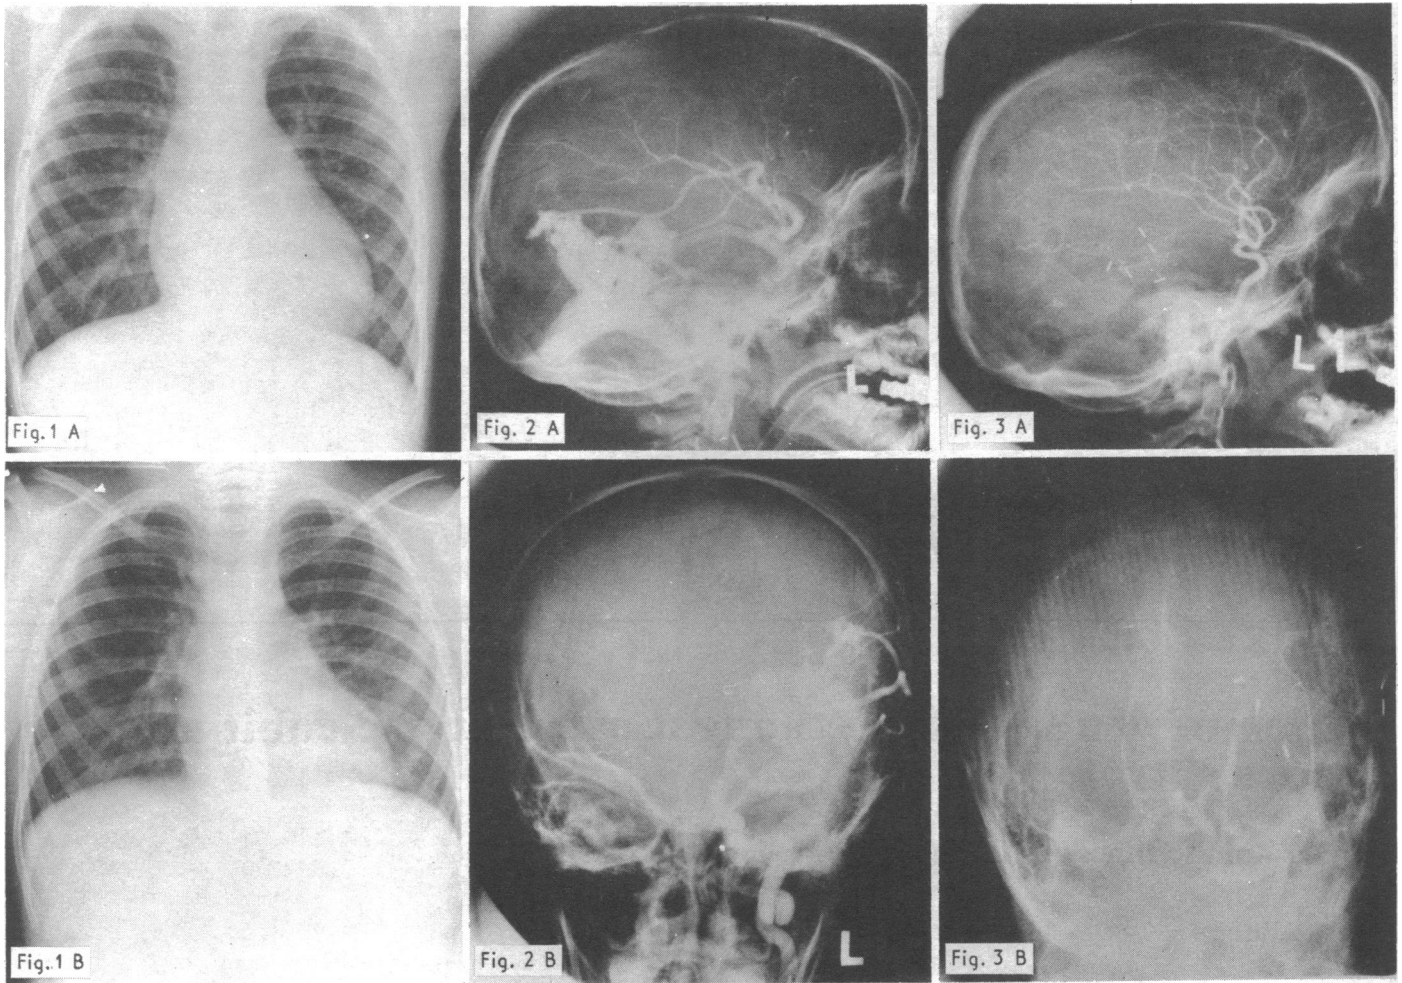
X-ray appearances of chest A, before operation showing enlarged heart; and, B, after operation showing normal heart. FIG. 2—Preoperative left carotid arteriogram (early stage). A, Lateral view showing enlarged left posterior cerebral artery and two branches of left middle cerebral artery supplying arteriovenous malformation draining into transverse sinus. B, Anteroposterior view showing internal carotid artery dividing into left posterior cerebral artery (medial) and left middle cerebral artery (lateral) to supply arteriovenous malformation. FIG. 3—Postoperative left carotid arteriogram (comparable stage). A, Lateral view. Internal carotid artery now supplies normal-sized anterior and middle cerebral arteries. Posterior cerebral artery fills faintly. There is no sign of the arteriovenous malformation. B, Anteroposterior view. Basilar artery and both posterior cerebral arteries are well shown filling via posterior communicating artery from internal carotid artery. Left anterior and left middle cerebral arteries are faintly shown in their normal positions.
